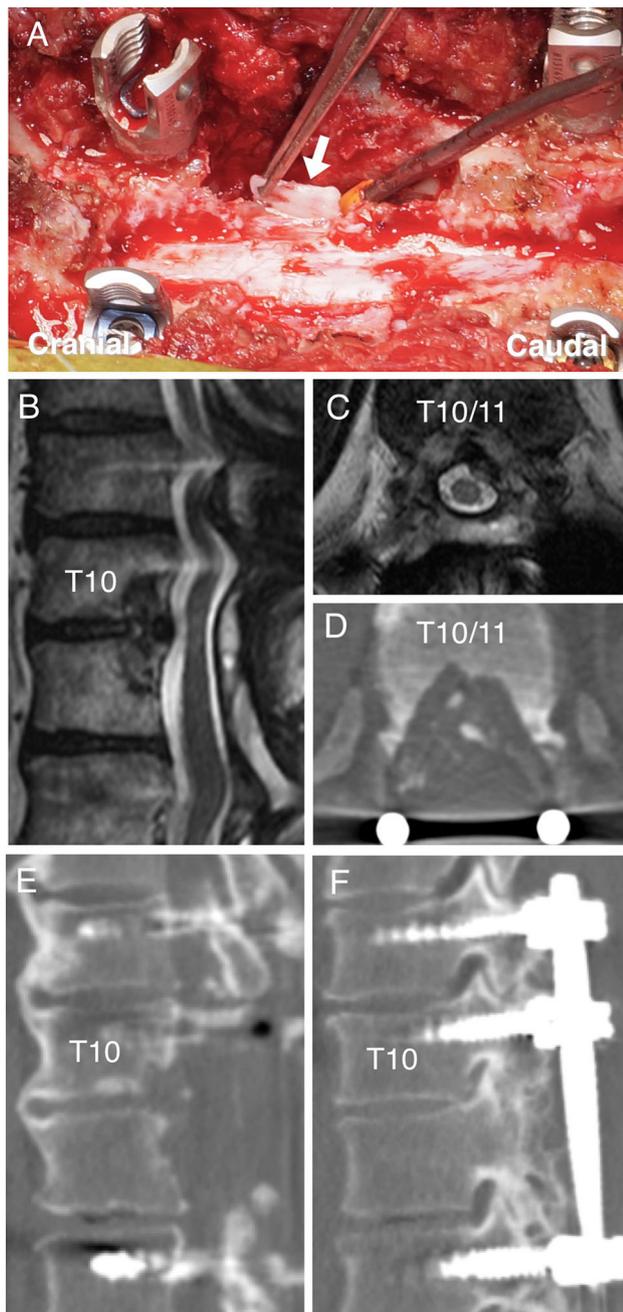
Case 2. Intraoperative photograph and MR images and CT scans obtained after the second operation. The recurrent OLF was removed at the T10–11 level (*arrow* in a). Sagittal (b) and axial (c) T2-weighted images show that the spinal cord is sufficiently decompressed at the T10–11 level after the second operation. An axial (d) and sagittal (e) CT scan shows that the OLF and OPLL as well as the medial facet joints on the bilateral sides are resected. Sagittal CT scan on the *left side* (f) shows the facet joints are fused at the T10–11 and T11–12
